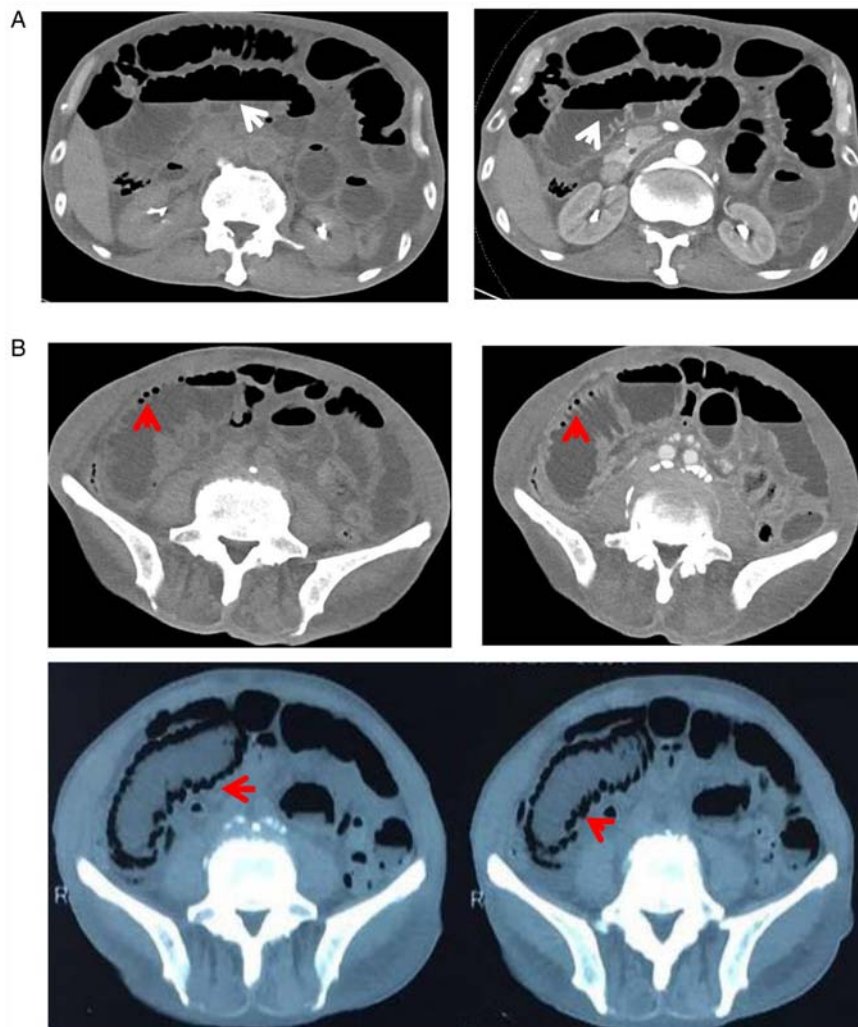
CT scans of the abdomen displaying (A) distension of the small bowel with pneumatosis and effusion (white arrow) and (B) distension of the small bowel with pneumatosis intestinalis (red arrow).
